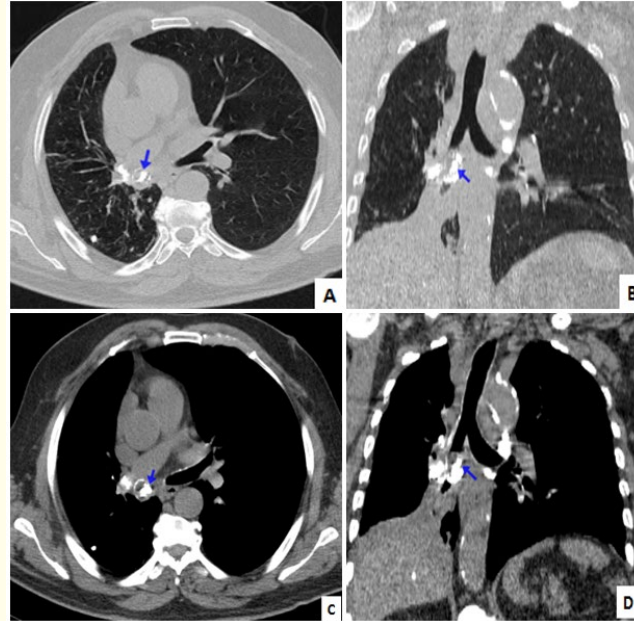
High-resolution chest CT in the parenchymal window (A and B) showing the right lower lobar bronchus that is dilated and contains dense material corresponding to broncholithiasis (blue arrow) better visualised in the mediastinal windows (C and D) associated with calcified inter bronchial adenopathies.
